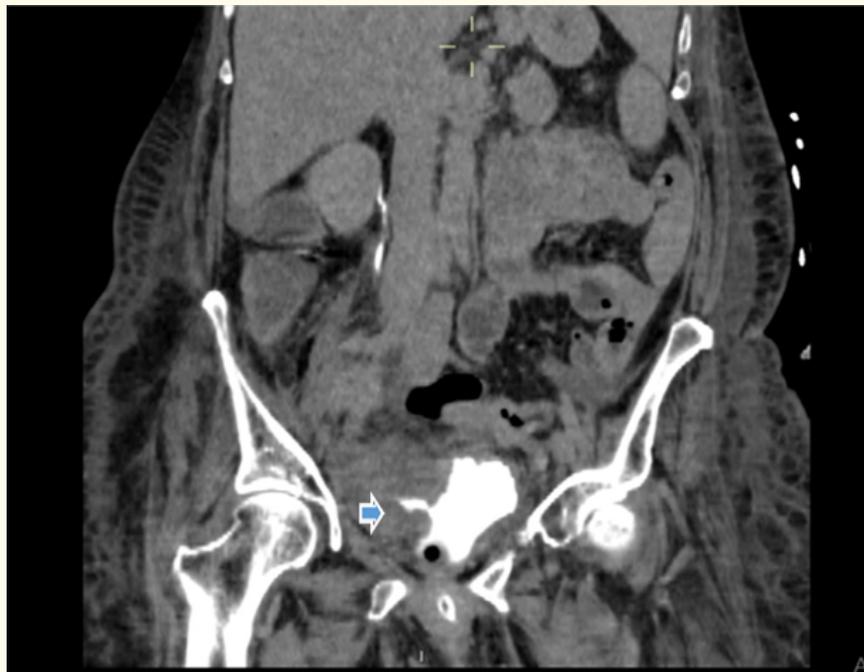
Contrast extravasation into the hyperdense hematoma on right hemipelvis as seen on CT cystogram-Coronal view- see blue arrow.
